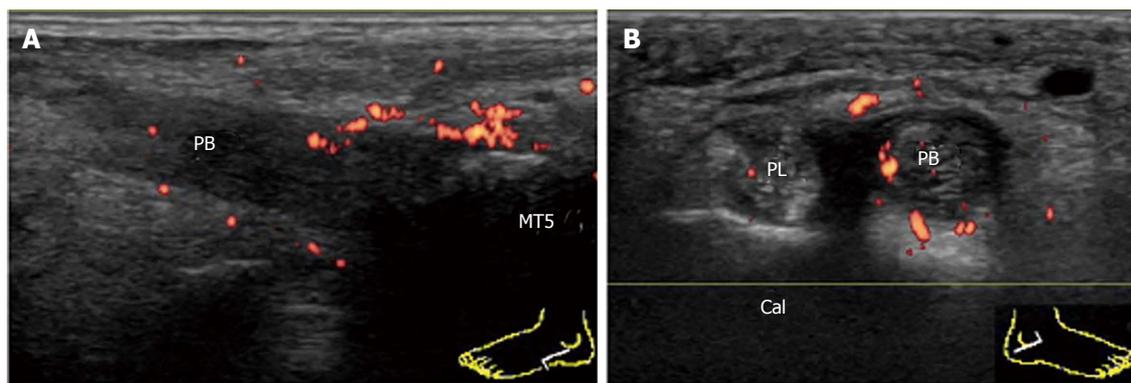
Involvement of peroneal brevis tendon in psoriatic arthritis. A: Enthesitis of the PB in psoriatic arthritis. Longitudinal power Doppler sonogram of the PB shows intratendinous hypoechoic change and loss of the fibrillar echoes with hyperemia adjacent to the insertion into the base of MT5. Cortical irregularities of the bone at the insertion are also depicted; B: Tenosynovitis of the contralateral PB in the same patient. Transverse power Doppler sonogram at the level of the peroneal tubercle of the Cal shows thickening and hyperemia of the PB tendon sheath. PL: Peroneus longus; PB: Peroneus brevis; MT5: The fifth metatarsal bone; Cal: Calcaneus.
